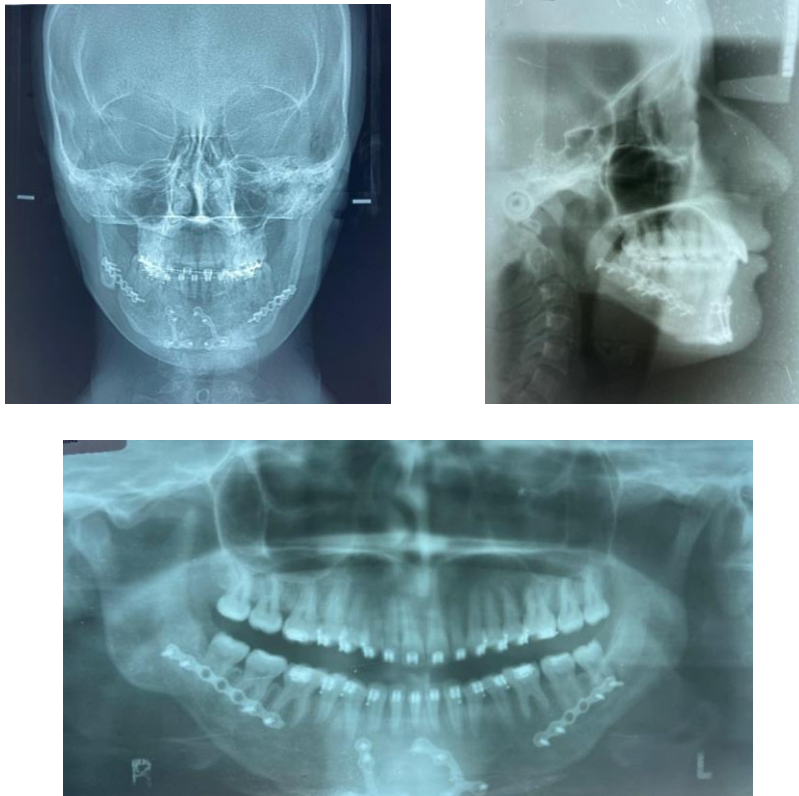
Radiographs of the patient at debonding
